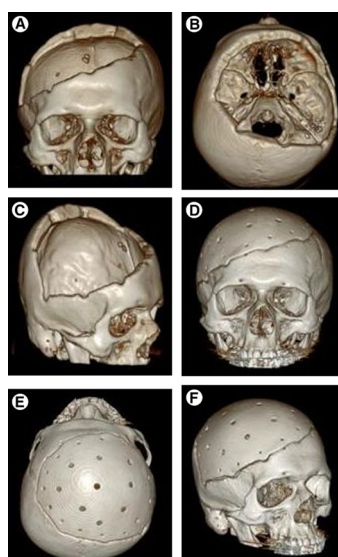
Three-dimensional computed tomographic images A-C, before versus D-F, after surgery show that the defect was successfully reconstructed.
